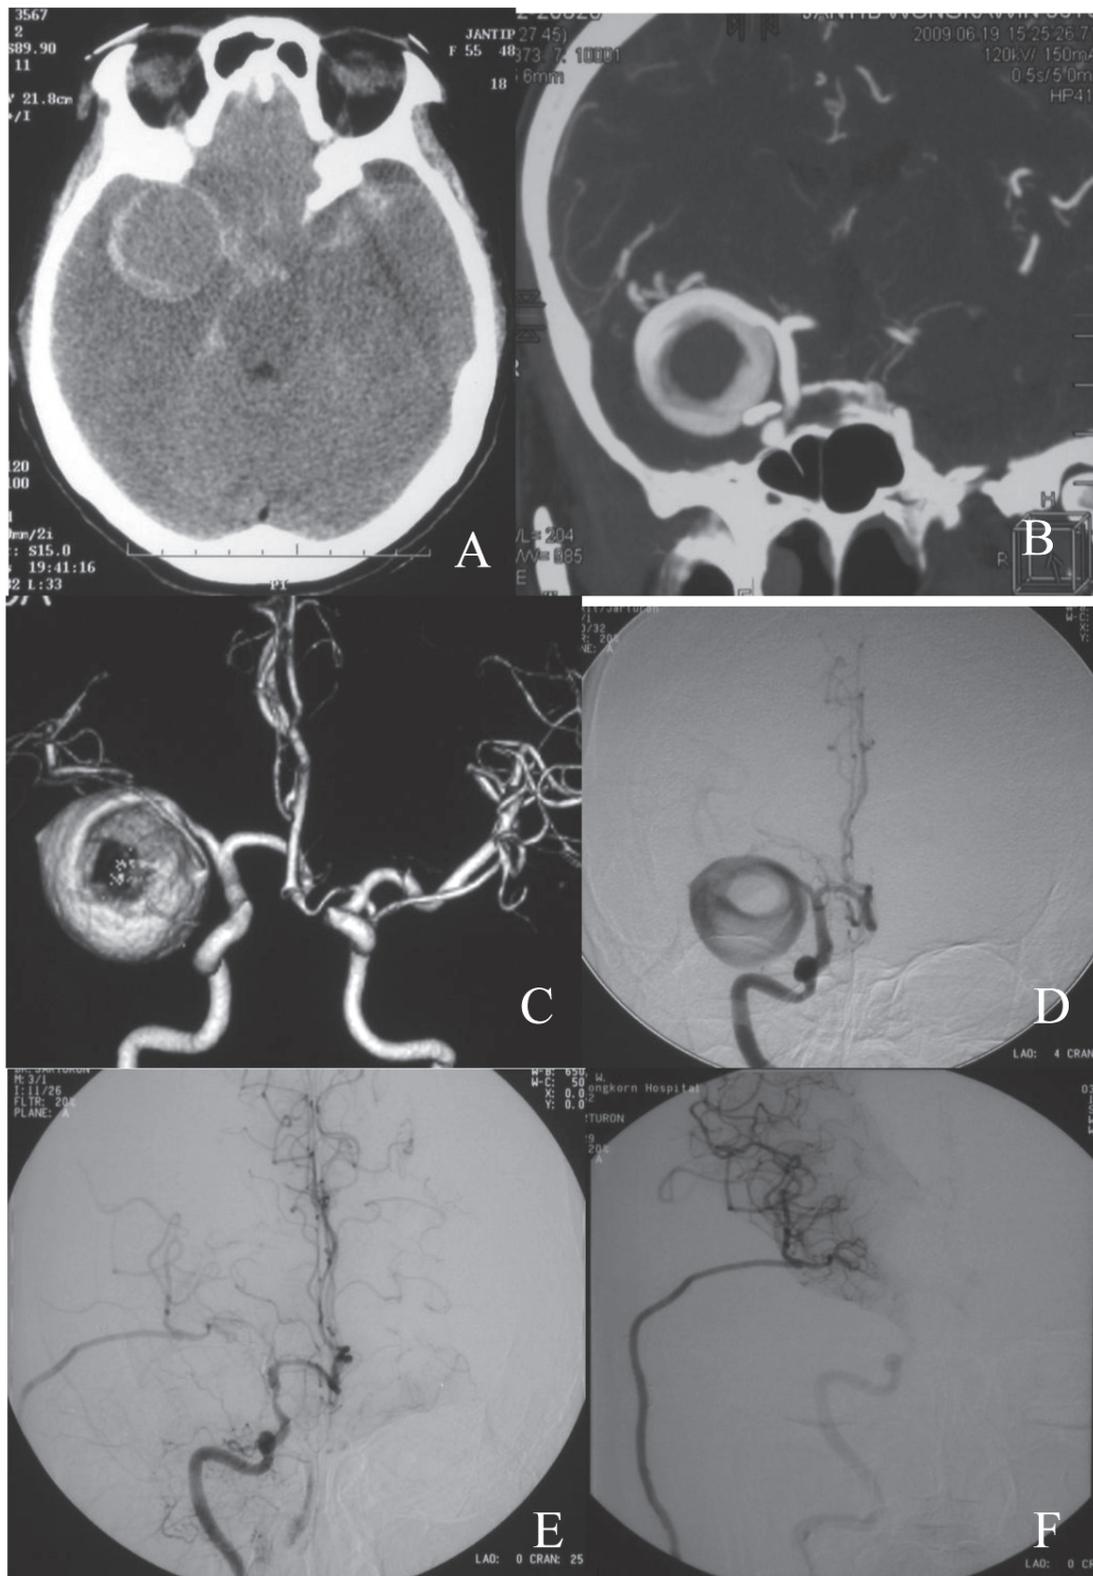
A 56-year-old female (case NO.11) presented with severe headache and loss of consciousness. A non-contrast CT scan (A) revealed a subarachnoid hemorrhage and partially thrombosed mass at right temporal region. CT angiography, 3D reconstruction angiography and digital subtraction angiography (DSA) revealed a giant right M1 aneurysm with turbulent flow (B,C,D). Right ECA-M2 bypass (radial artery) with proximal occlusion of right M1 was performed. Post-operative DSA (E,F) showed a well obliterated aneurysm and patent bypass graft. The patient had no focal deficit at immediate postoperative period and at 7-month follow-up.
